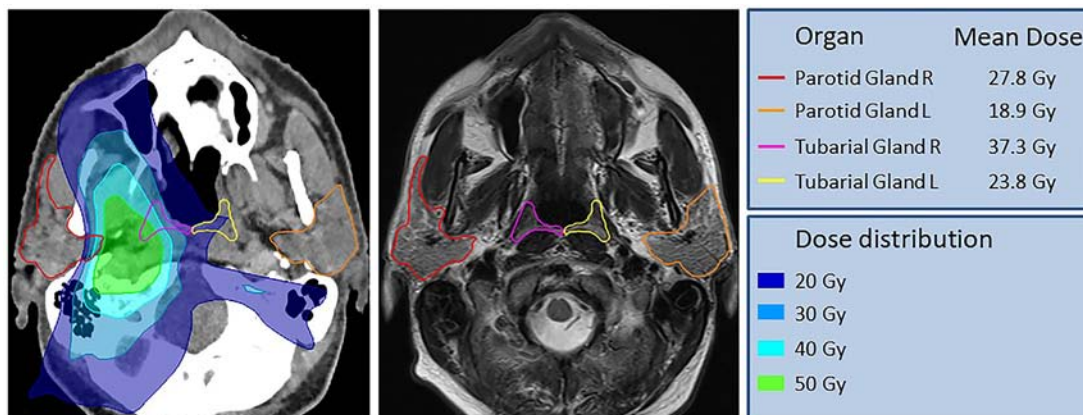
Radiotherapy evaluation of region of the torus tubarius with overlying gland. Evaluation of radiotherapy dose to the newly described glands overlying the torus tubarius: Axial CT-slice with projected radiation dose distribution as color-wash (left) and MR-slice (right, 3-Tesla, T2-dixon with gadolinium) of a 53-year old patient who received radiotherapy for cT3N1M0 oropharyngeal cancer.
